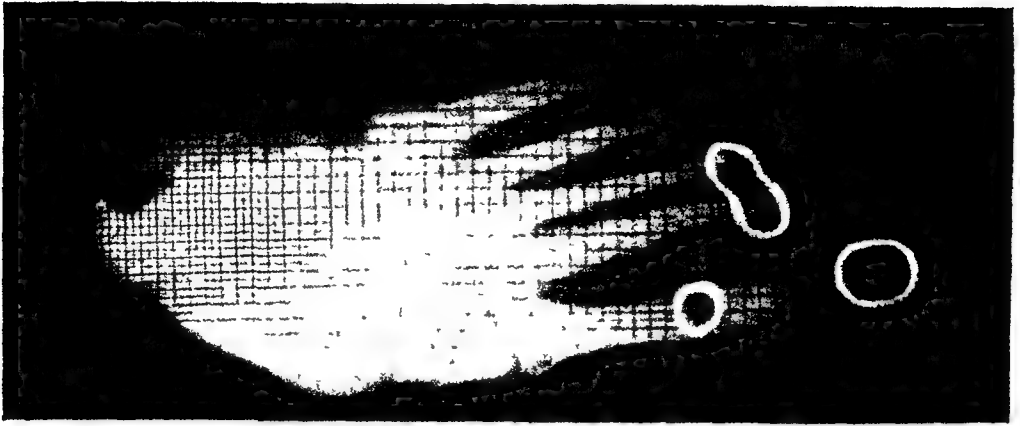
ORTHODYNAMIC RADIOGRAPH (X-RAY PAPER) Short first metatarsal pattern excess imprint to medial sesamoid, second and third metatarsophalangeal joints, and interphalangeal joint area of great toe
